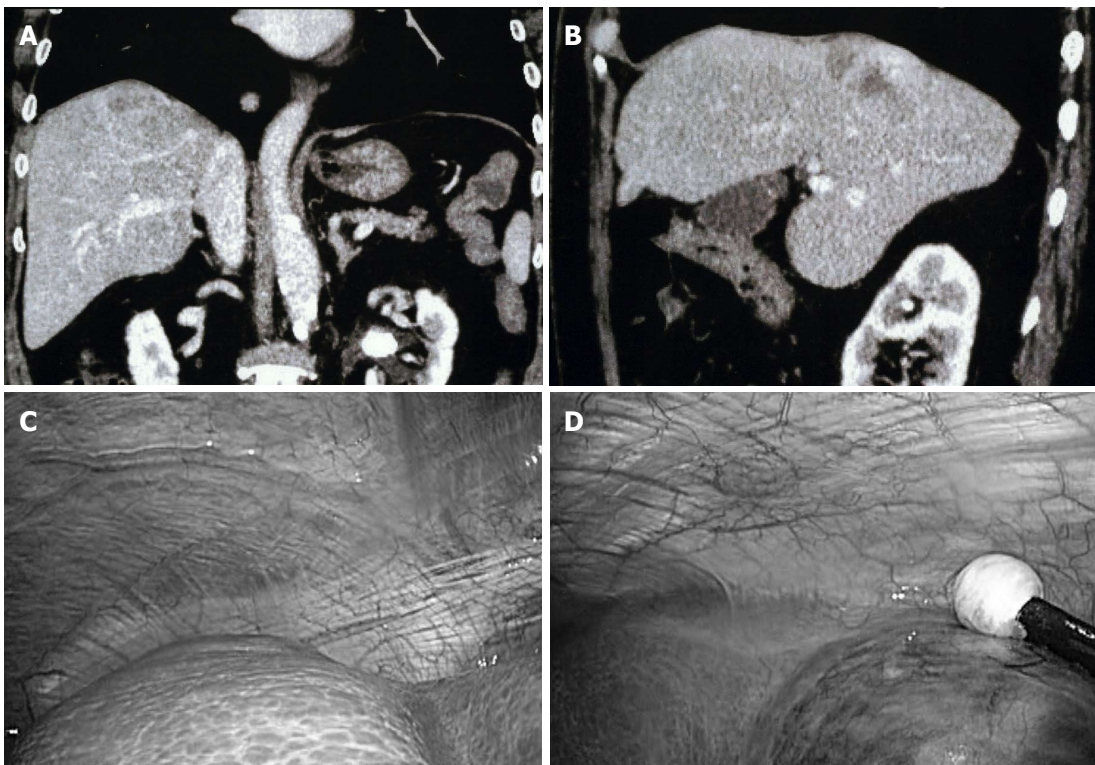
Pure laparoscopic hepatectomy is efficient in the subphrenic space: case 2. An 80-year-old woman with liver cirrhosis developed a hepatocellular carcinomas in the dorsal area of subsegment 8c of the liver revealed in computed tomography examination (A and B). Since the tumor compressed the right hepatic vein and her liver function seemed not to tolerate right hepatectomy or extended anterior sectionectomy, she underwent partial resection of the liver with the dissection and exposure of right hepatic vein and tumor capsule in pure laparoscopic hepatectomy. The tumor was located deeply in the subphrenic space (C) just next to the attachment of retro-peritoneum (D).
